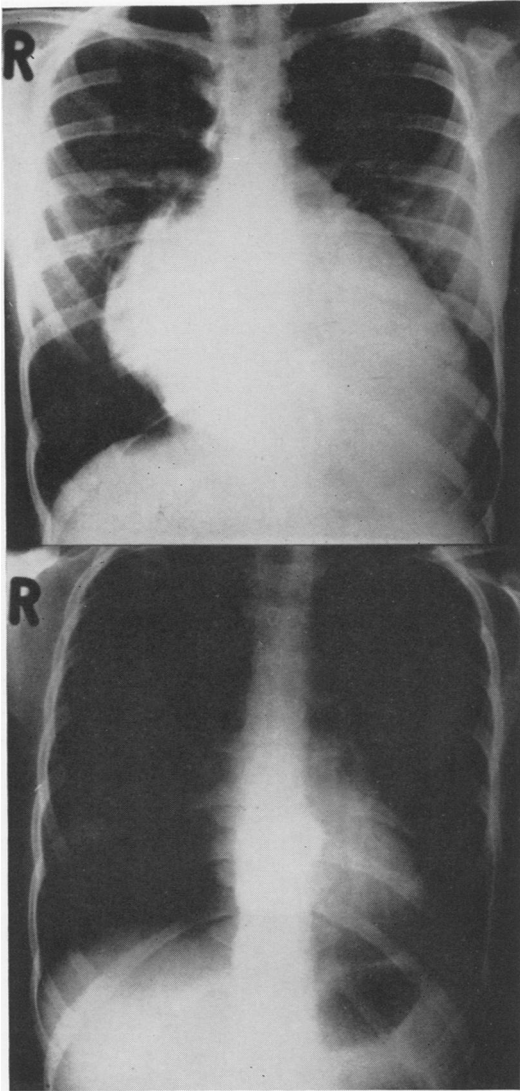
(a & b). Patient 3: Pre- (top) and post-operative (bottom) chest x-rays of a 14-year-old girl. This patient died 15 months after operation due to embolic complications from the disc valve.
